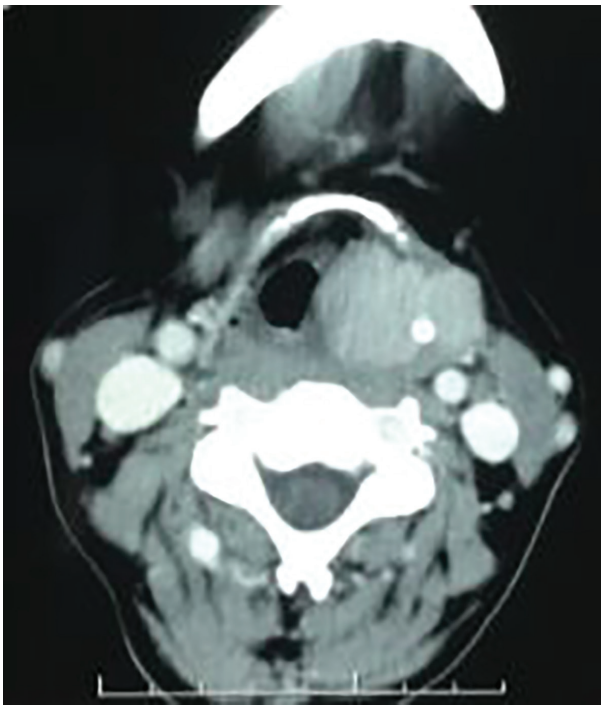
CT-scan of the neck showing a soft tissue mass in left pyriform sinus and aryepiglottic fold encasing hyoid bone, thyroid cartilage and vocal cord on the left.
